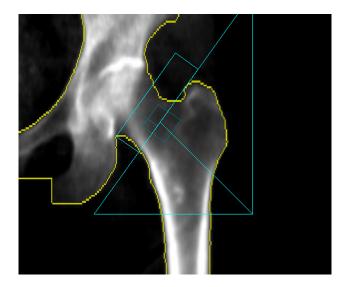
A representative dual-energy X-ray image used for bone mineral density assessment. The yellow lines indicate the boundaries of the hip bones, while the blue lines represent the regions of interest used for bone density analysis. All lines were automatically generated by the enCORE software (v.17.0, GE Healthcare, Madison, MI, USA).
